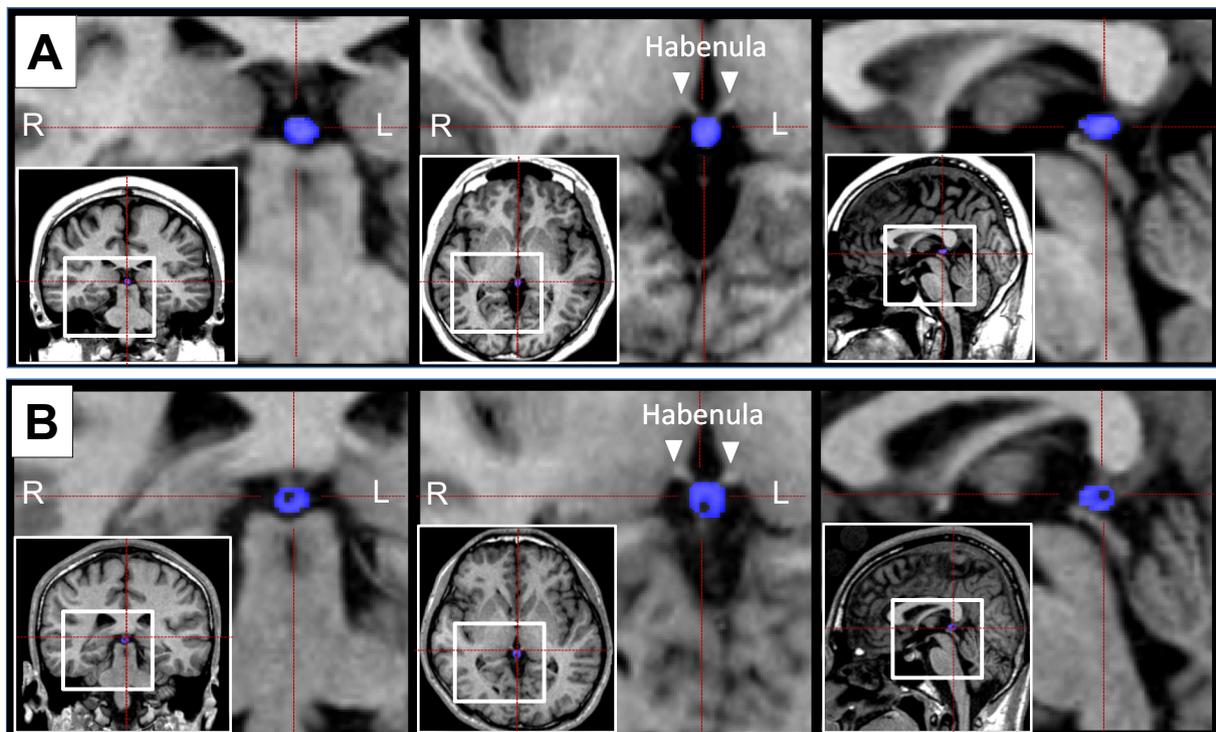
Coronal (left), axial (middle), and sagittal (right) views of sample MR images of the pineal gland (colored in blue) in subjects without (A) and with (B) a pineal cyst. The pineal gland was automatically delineated from surrounding cerebrospinal fluid space by using the signal intensity histogram, except for the attachment to the habenulae (i.e., the pineal stalk) that was excluded from the measurement of the pineal gland. L, left; R, right.
